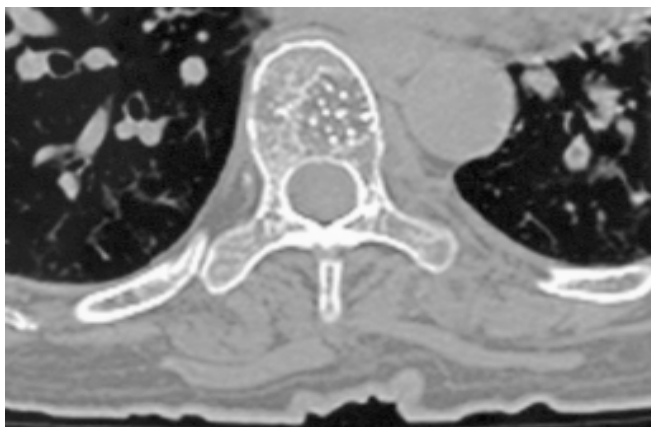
CT of thoracic spine showing polka dot appearance of the vertebra.
